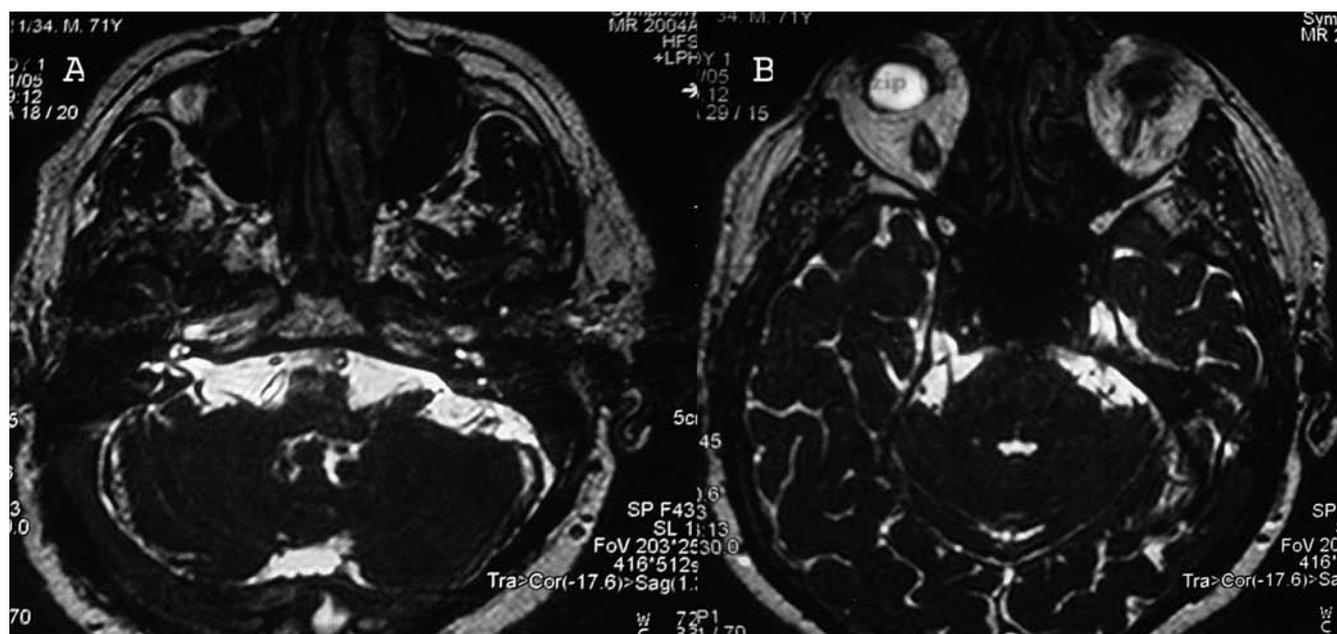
a MRI demonstrating an ectatic vessel causing impingement of the right facial nerve. b Aberrant vascular loop compressing the trigeminal nerve
